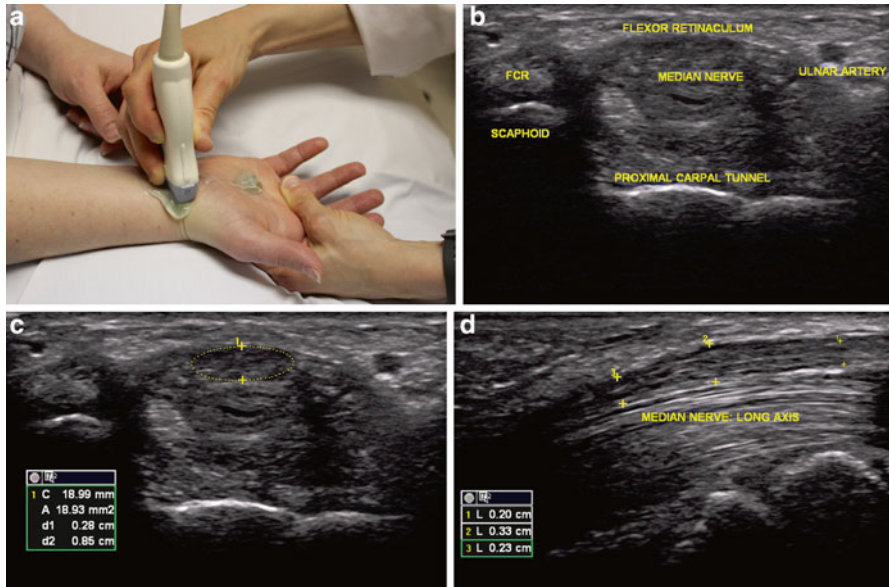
Ultrasound imaging of the carpal tunnel. (a) Proper positioning of the patient and ultrasound transducer for carpal tunnel ultrasound. (b) Ultrasound image of an enlarged median nerve as it passes through the carpal tunnel; *FCR* flexor carpi radialis. (c) Measuring the cross-sectional area of an enlarged median nerve (18.93 mm²) within the carpal tunnel on ultrasound; *C* circumference, *A* Area, *d1* height, *d2* width. (d) Long axis view of the median nerve with increased dimensions noted centrally at the level of the carpal tunnel (measurement 2) in comparison to more proximal and distal measurements; *L* length
